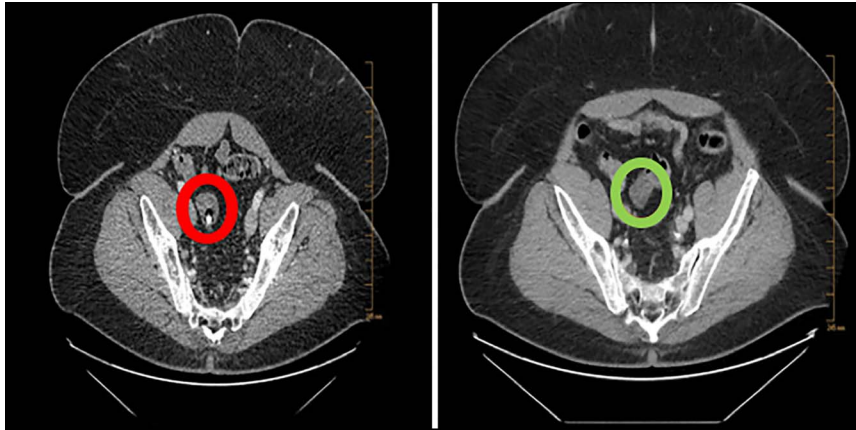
Computed tomography (CT) scan image showing the capsule retained within a MD (red circle). Image of follow-up CT scan 6 months later showing the same MD (green circle) indicating spontaneous passage of the previously retained capsule. MD, Meckel's diverticulum.
